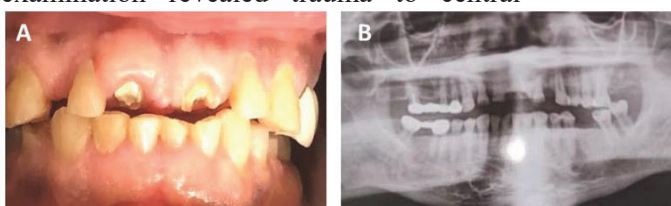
Preoperative images: A. Intraoral clinical image showing both maxillary central incisors with fractured crowns; B. Preoperative Orthopantomograph
